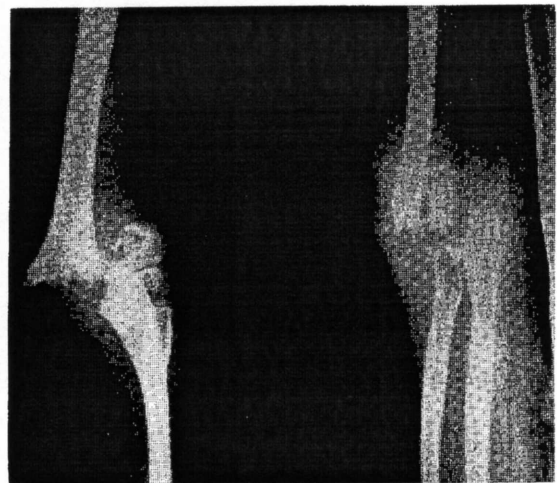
Roentgenogram in this instance shows severe displacement.
